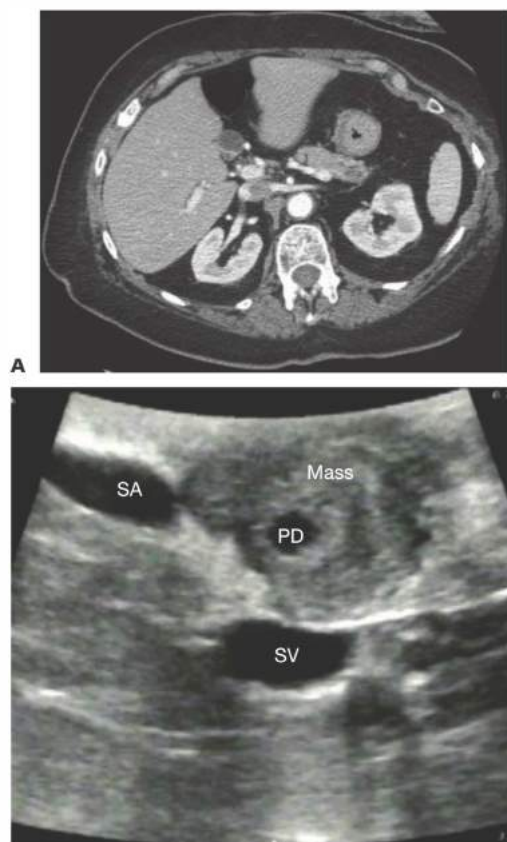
• A. Venous-phase CT showing an irregular hypodensity in the pancreatic tail. This was proven to be a ductal adenocarcinoma on EUS/FNA. B. IOUS image showing an irregular, hypoechoic mass in the pancreatic tail around the pancreatic duct (PD). The mass abuts both the splenic vein (SV) and the splenic artery (SA).
